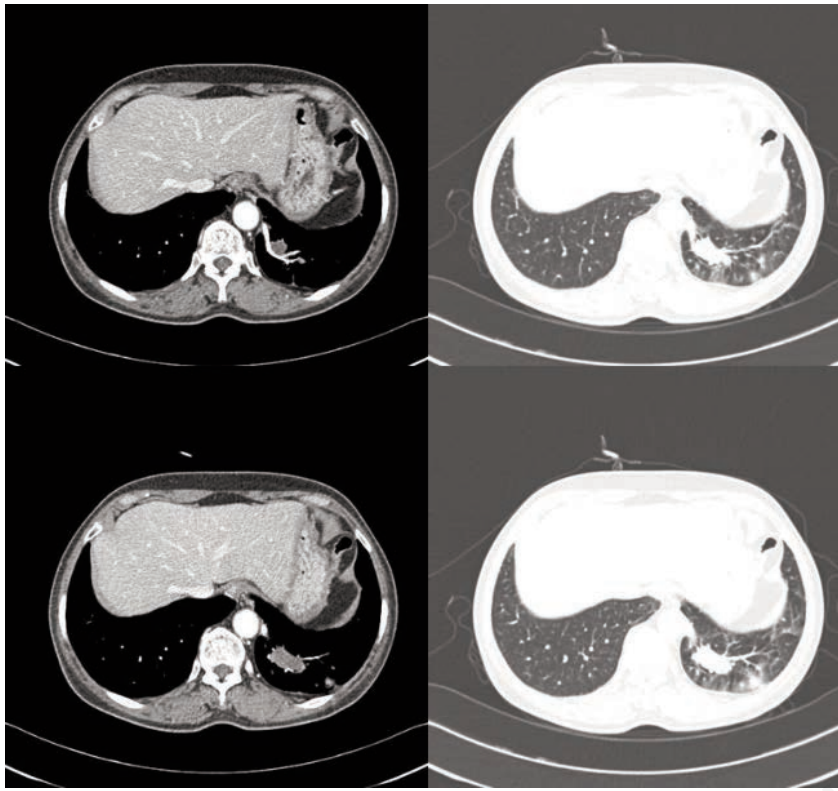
About 14.0×11.4 mm sized low density mass like lesion in the left lower lobe which is supplied by the artery originating from the thoracic artery is observed in CT scan taken in 2008.
